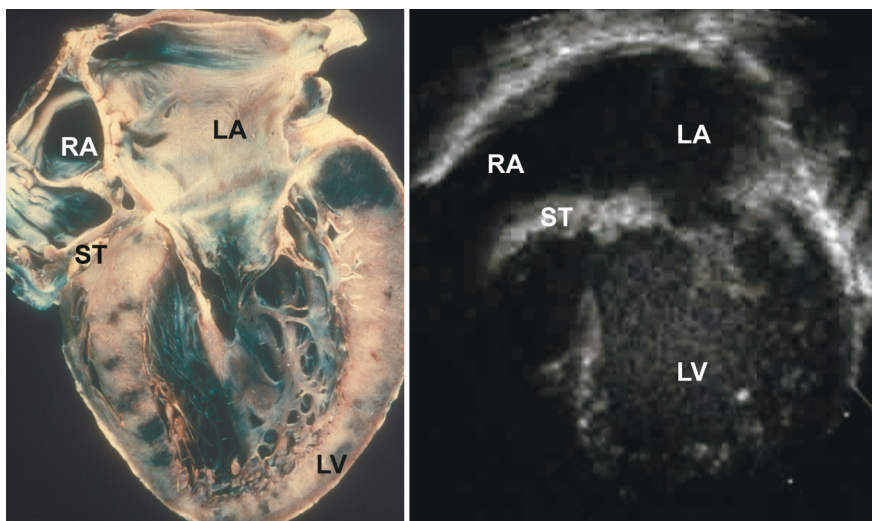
Apical four-chamber view of univentricular connection of the left ventricular type with absent right connection (tricuspid atresia). Note the wedge of sulcus tissue in the floor of the right atrium. LA = left atrium; LV = left ventricle; RA = right atrium; ST = sulcus tissue.
